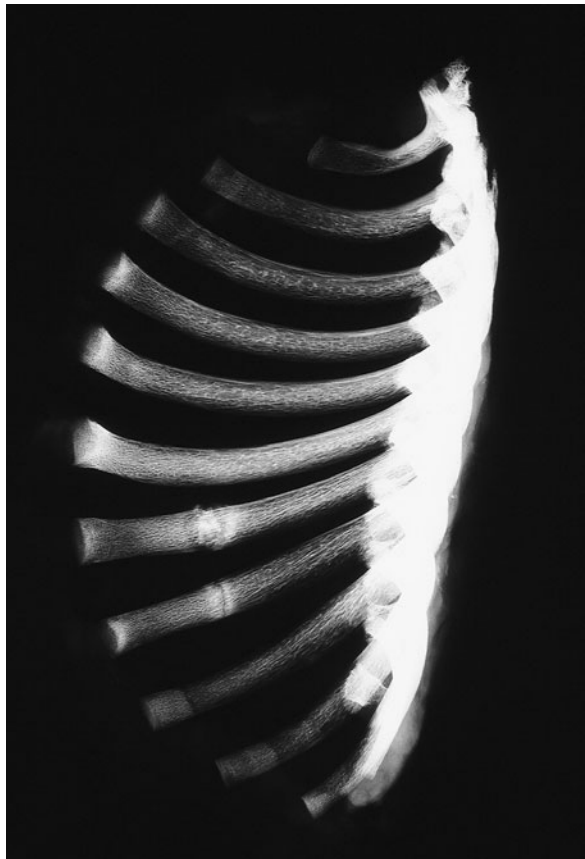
Radiographic images from mammography machine of right rib fractures
